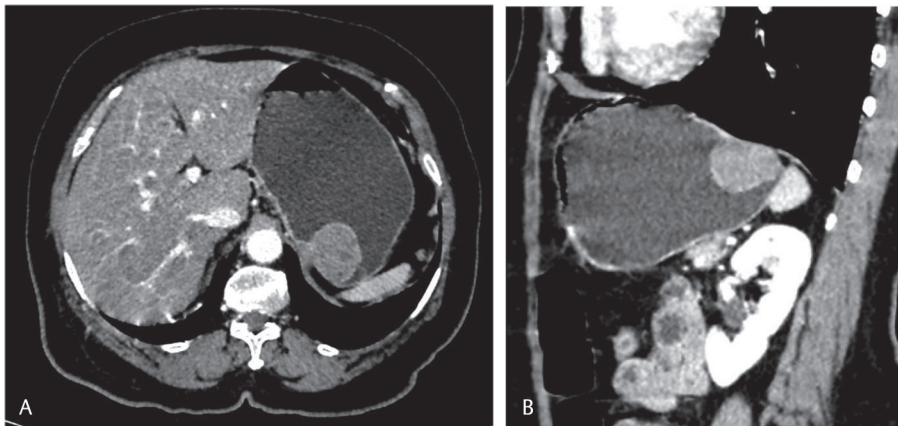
(A) Axial and (B) sagittal reformatted contrast-enhanced CT images of 64-year-old female with totally endophytic gastric gastrointestinal stromal tumor (GIST). Size 3.7 cm. Mitotic index (MI) $< 5/50\text{ HPF}$. Low risk.
